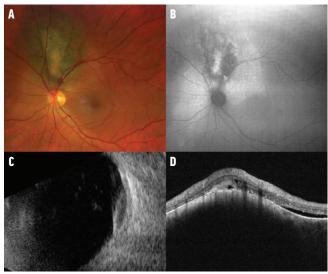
Fundus imaging shows choroidal melanoma superior to the optic disc in a 49-year-old woman (A). Fundus autofluorescence demonstrates orange pigment in the central part of the tumor (B). B-scan ultrasonography shows characteristic acoustic hollowness (C). OCT overlying the tumor depicts serous retinal detachment (D). This patient had a fine needle aspiration biopsy at the time of plaque radiotherapy for genetic testing, and results came in as chromosome disomy 3, 6, and 8, consistent with TCGA Group A. This lowrisk cytogenetic profile suggests a 6% risk for metastasis at 10 years.
